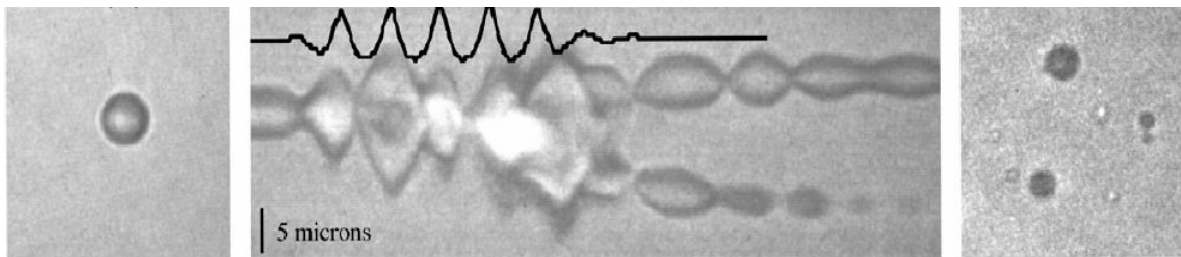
Optical images of a 2.5 μm -radius microbubble exposed to ultrasound [2].
